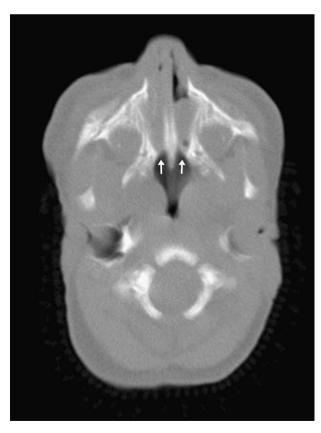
Axial CT scan showing mixed bilateral choanal atresia (arrow). Distance from posterior vomer to lateral pterygoid plate is 2.1 mm on each side.
